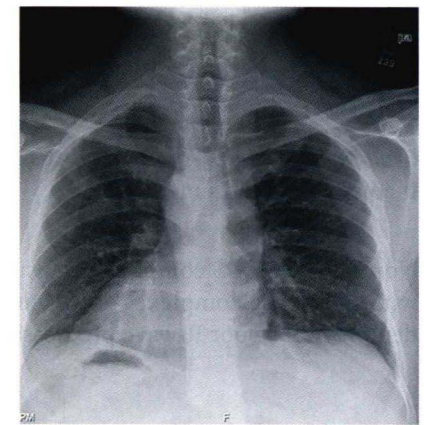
This patient's chest x-ray, demonstrating situs inversus.
